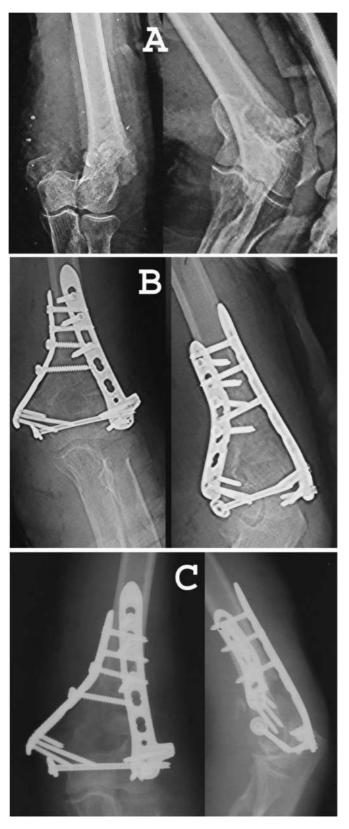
A- Case 2- TRAP; Pre-operative Xray showing intercondylar fracture humerus. B- Case 2- TRAP; Post-operative follow up Xray 4 weeks. C- Case 3- TRAP; Post-operative Xray follow up at 12 weeks.
